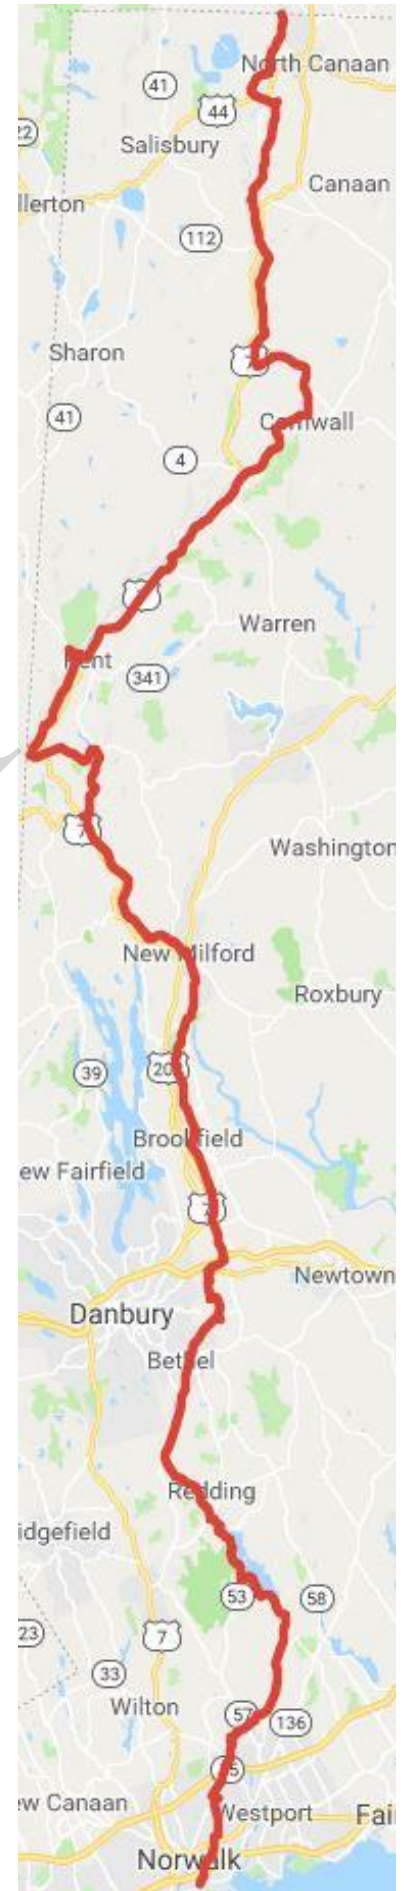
CT segment of the Western New England Greenway on-road route
